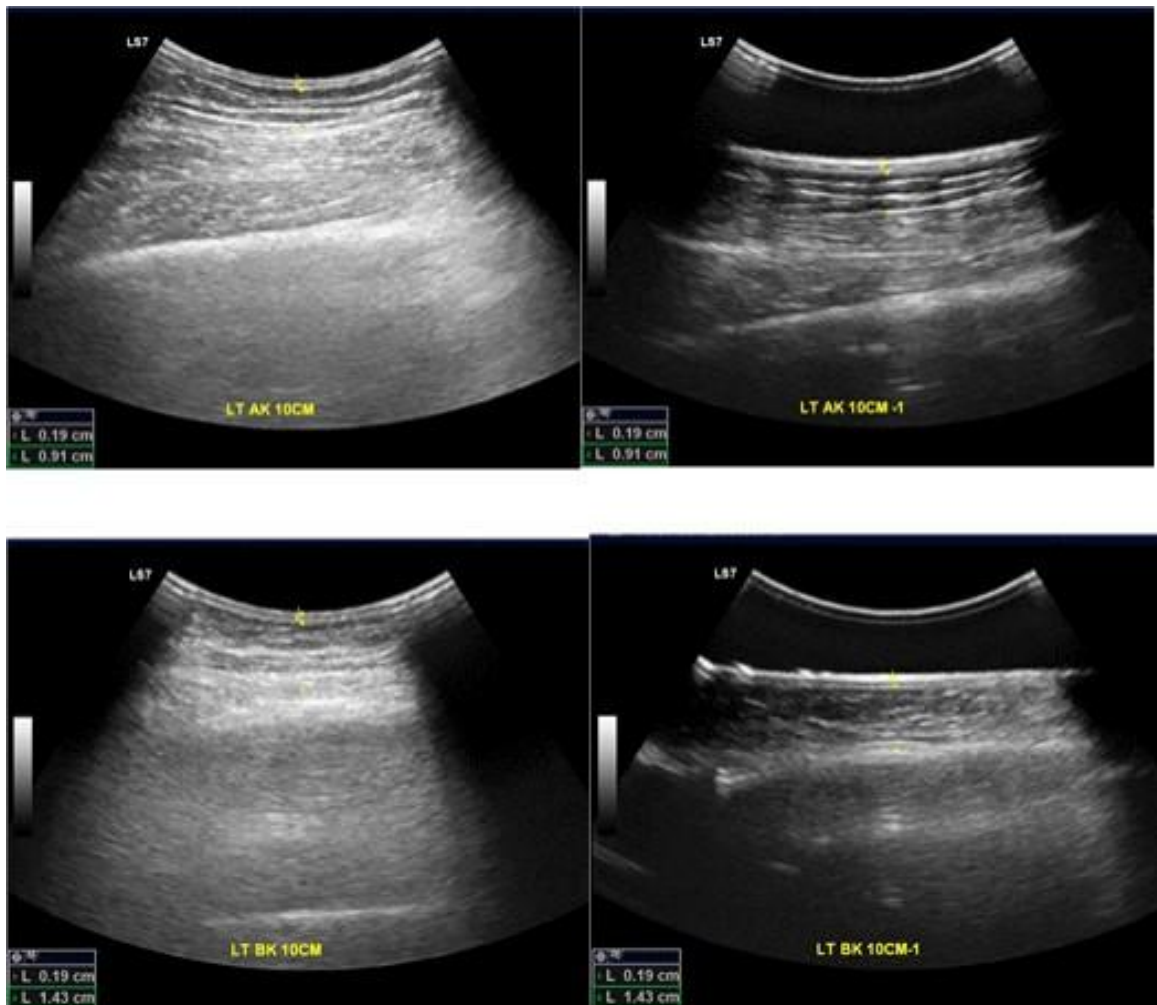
Example of skin and subcutaneous thickness measured by ultrasonography
